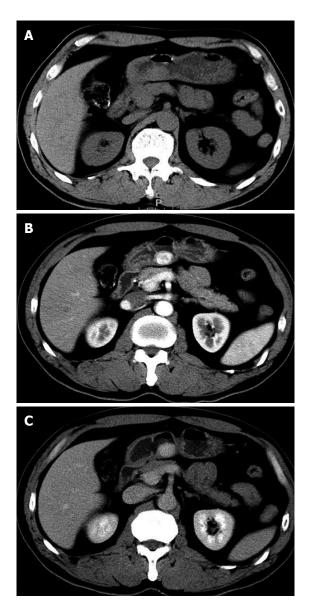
A 57-year-old man presented with intermittent dull abdominal pain after a duration of 1 year with a glomus tumor in the lesser curvature. A: A plain computed tomography (CT) scan of the tumor revealing a clear regular contour and an isodensity mass; B: The mass shows dense homogeneous enhancement with an intact overlying mucosa on early-phase contrastenhanced CT; C: The mass shows continuous homogeneous enhancement on delay-phase contrast-enhanced CT.
